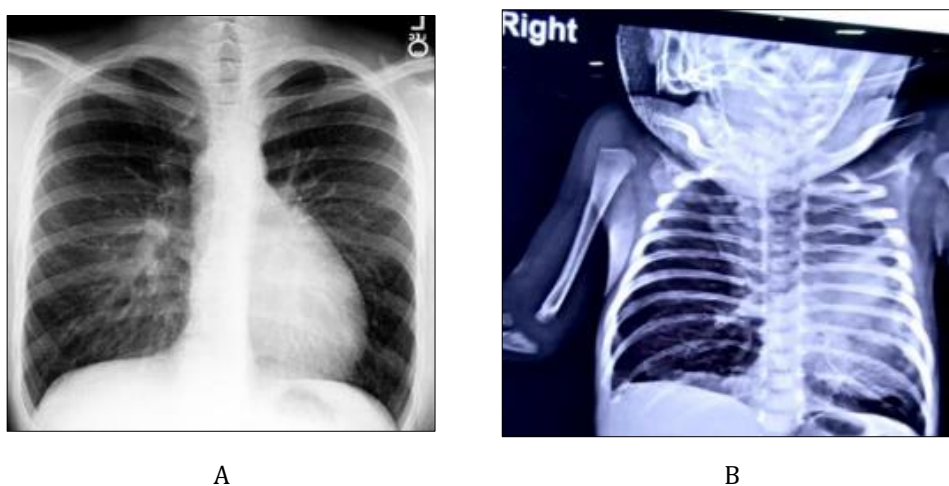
(A) X-ray chest PA of another patient with TGA. There is a classical “egg on string appearance”. (B) Our index patient X-ray chest AP view. Resembling the “egg on string appearance”
